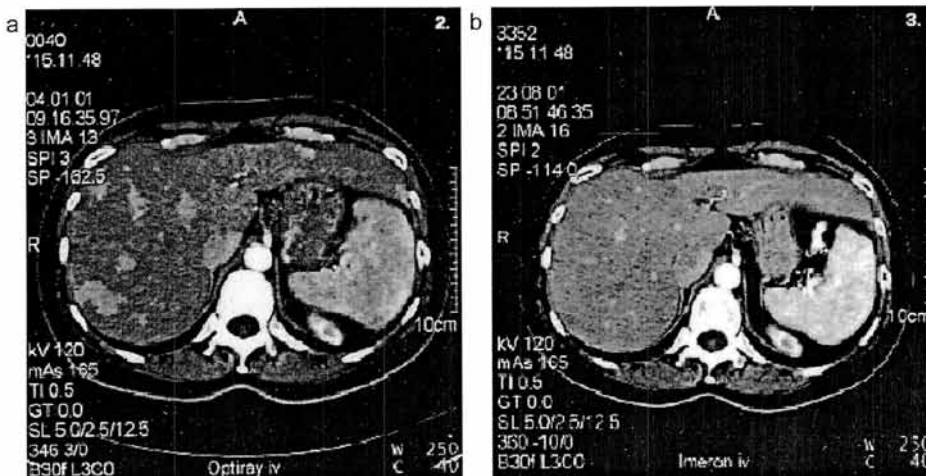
a. Pre-therapeutic CT-scan of the patient shown in Figure 1. Multiple liver metastases can be seen. b. CT-scan 3 months after the second treatment of the same patient. Liver metastases are no longer demonstrated.
